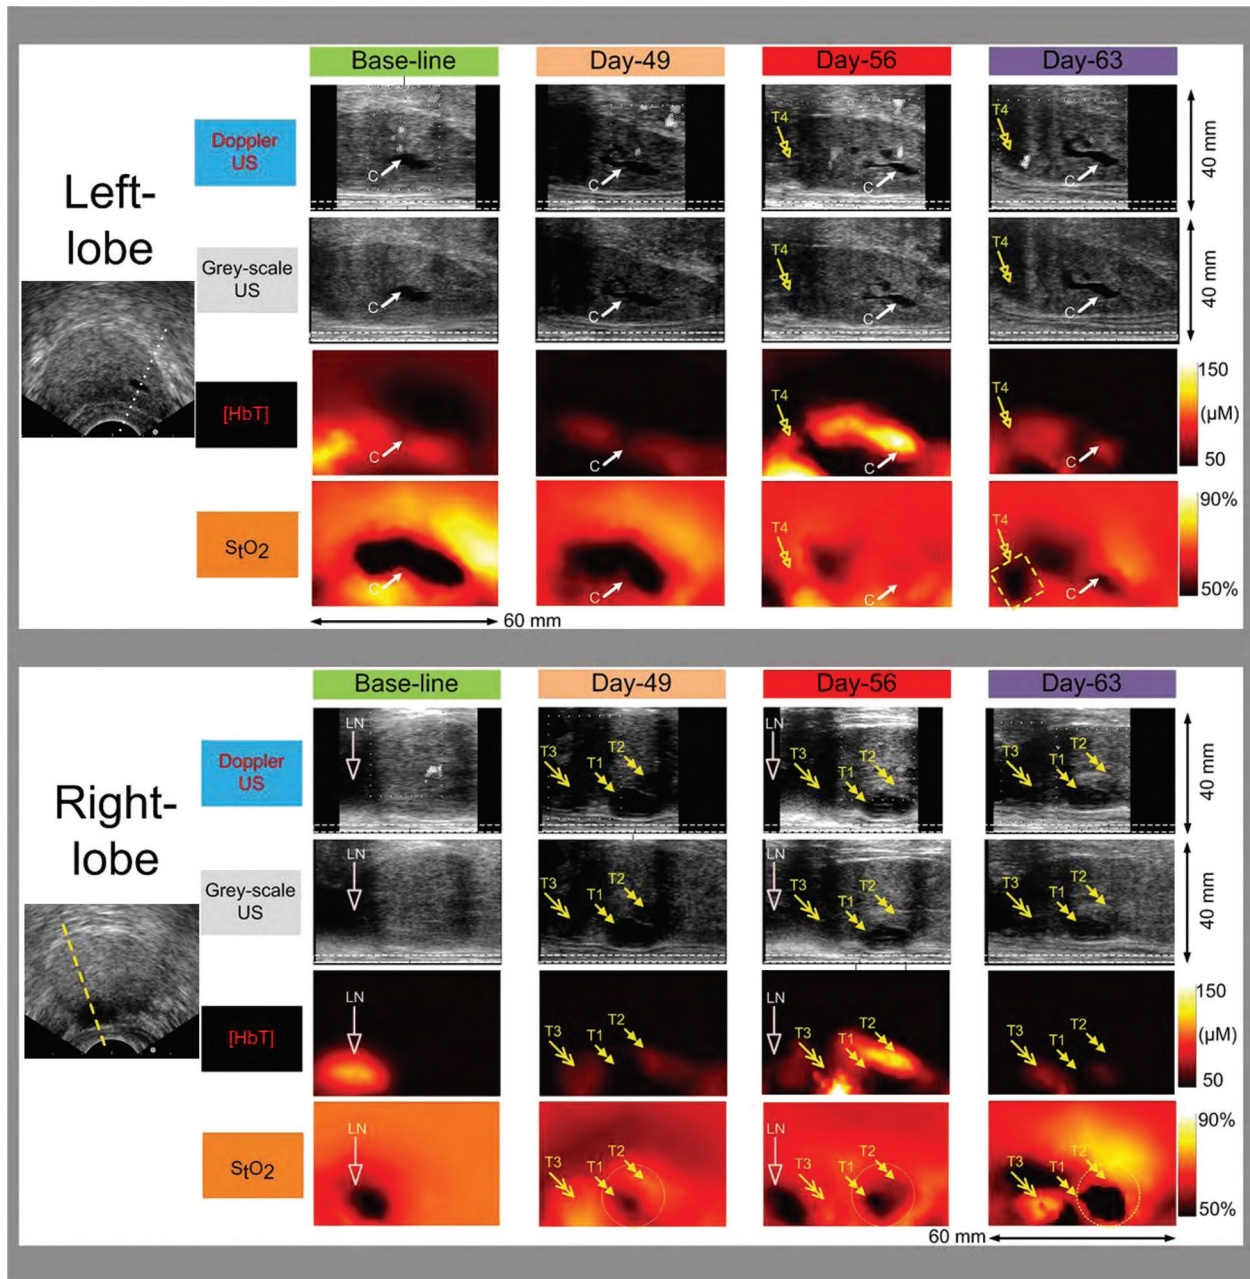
Image dimension—60 mm × 40 mm (cranial-caudal × dorsal-ventral). Images were acquired at base-line, day-49, day-56 and day-63 after the injection, for Doppler US, grey-scale US, [HbT] and S_tO_2 , at left-mid-sagittal plane across the cyst (marked by the dotted line across the axial US image in the upper panel for the left-lobe) and right-mid-sagittal plane across the planned TVT injection site as well as a later developed tumor mass (marked by the dashed line across the axial US image in the lower panel for the right-lobe). The dashed line at the dorsal edge of the US images indicates the actual location of the NIR sensors at approximately 3 mm ventral to the surface of the US transducer. The color-scales for NIR images are (50-150) μM for [HbT] and (50-90)% for S_tO_2 , respectively. C indicates cyst; LN indicates lymph node; T indicates tumor.
